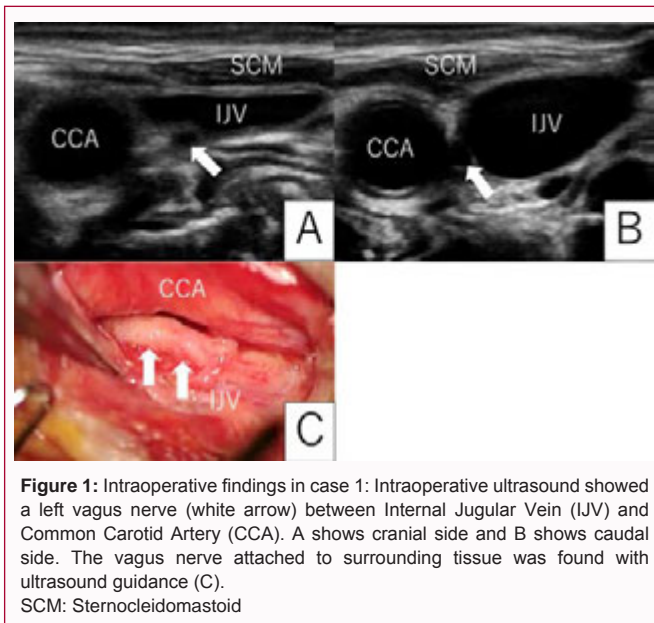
Intraoperative findings in case 1: Intraoperative ultrasound showed a left vagus nerve (white arrow) between Internal Jugular Vein (IJV) and Common Carotid Artery (CCA). A shows cranial side and B shows caudal side. The vagus nerve attached to surrounding tissue was found with ultrasound guidance (C).
